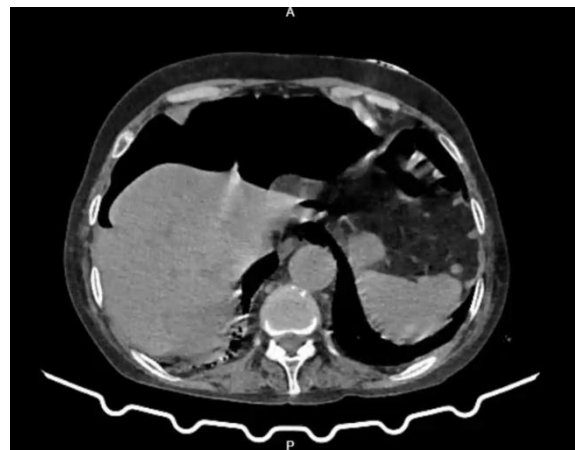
CT of abdomen showing pneumoperitoneum before pigtail insertion
